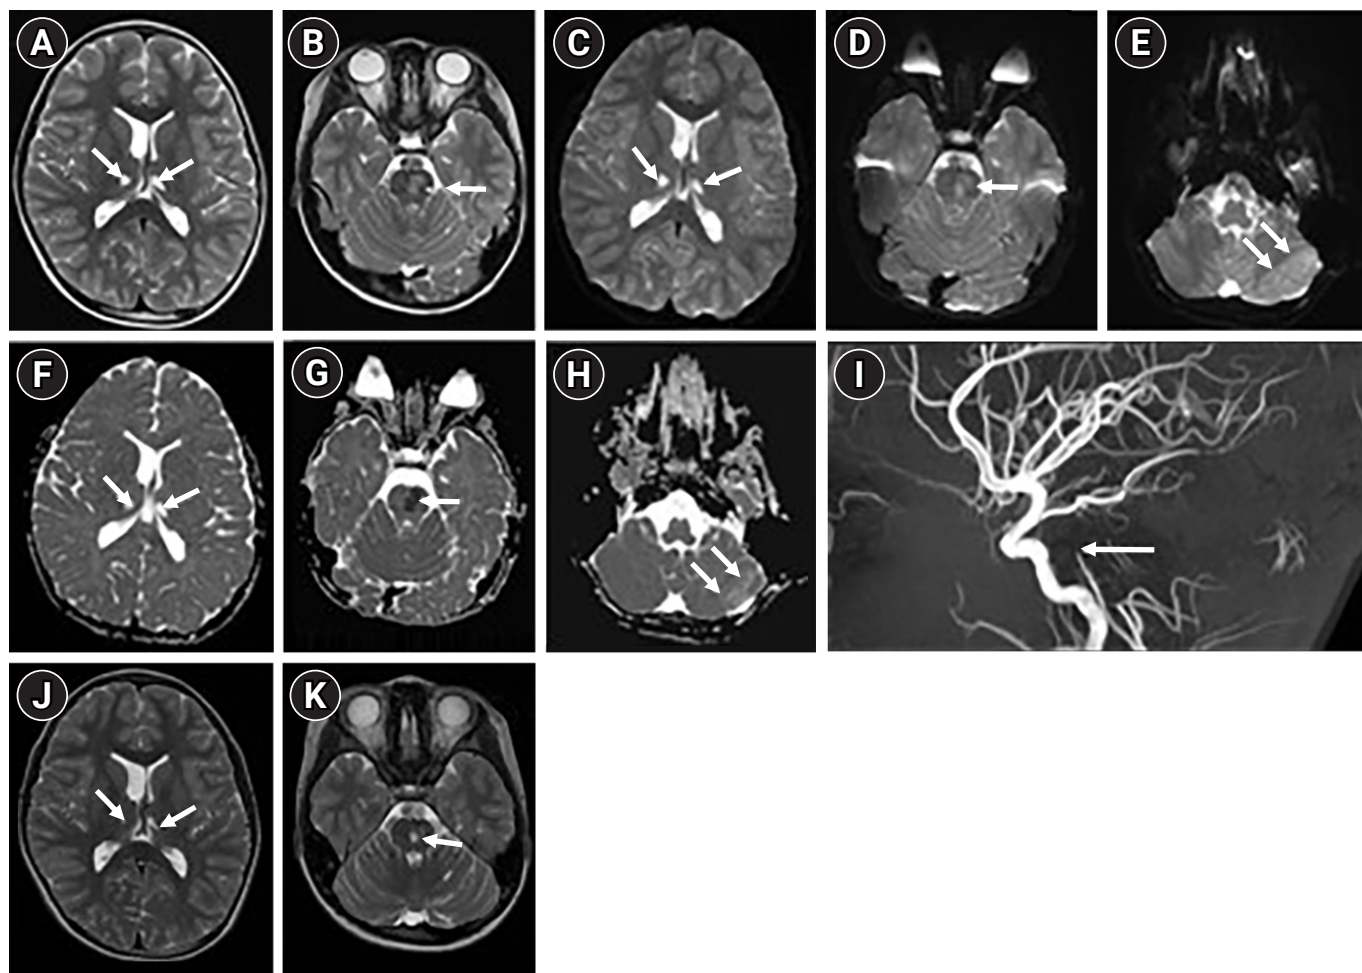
Top of the basilar syndrome in a 4-year-old boy. Initial T2-weighted (A, B) images, diffusion-weighted images (C, D, E) and the apparent diffusion coefficient value (F, G, H) reveal bilateral symmetrical lesions in the posteromedial aspect of both thalami (white arrows), the pons (white arrow), and left cerebellar cortex (white arrows). Three-dimensional magnetic resonance angiography with the time-of-flight technique (I) shows no demonstrable flow signal intensity in the distal basilar artery (long white arrow) and both superior cerebellar arteries (white arrows). Follow-up T2-weighted images (J, K) reveal decreased sizes of the encephalomalacic lesions in both thalami and pons (white arrows).
